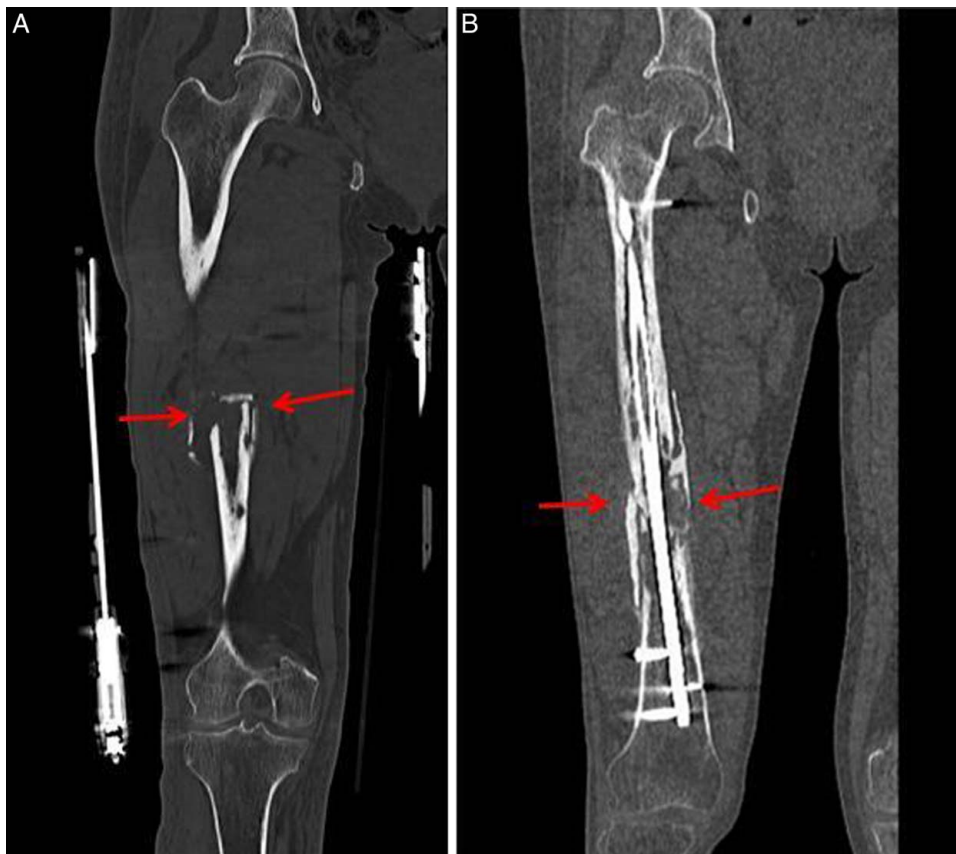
(A) is the preoperative computed tomography (CT) scan image, and (B) is the CT scan image at the 6th month after operation.
